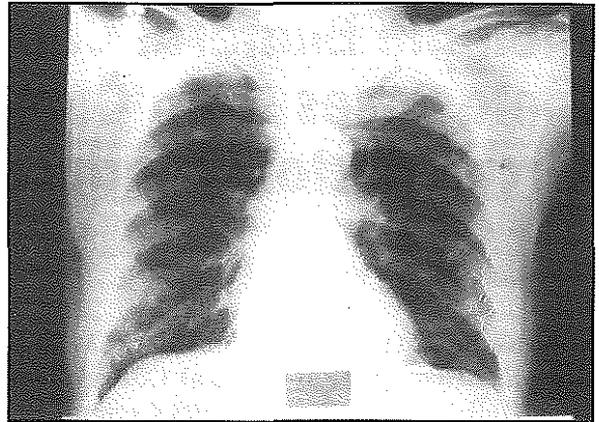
Chest x-ray 3 months following bilateral orchidectomy and flutamide. Note the improvement in both lung fields.
